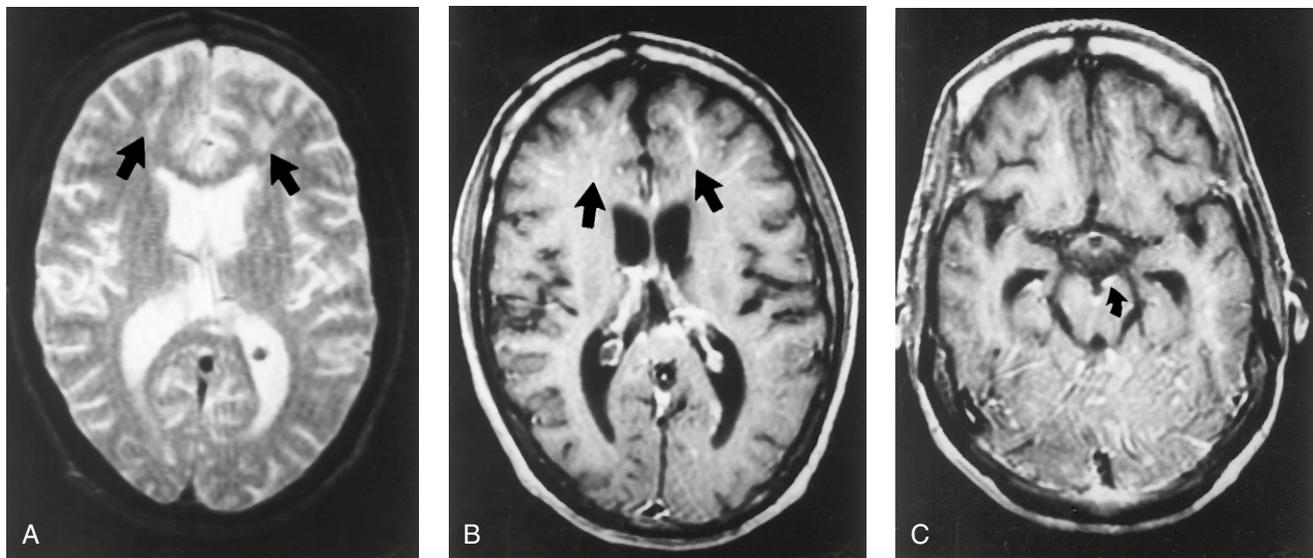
Cryptococcal meningoencephalitis. (A) Axial T2-weighted image shows abnormal increased signal in the frontal lobes (arrows). (B) Axial T1-weighted image with gadolinium shows abnormal enhancement within areas of cerebritis in the frontal lobes (arrows). (C) Axial T1-weighted image with gadolinium shows abnormal meningeal enhancement around the midbrain (curved arrow).
